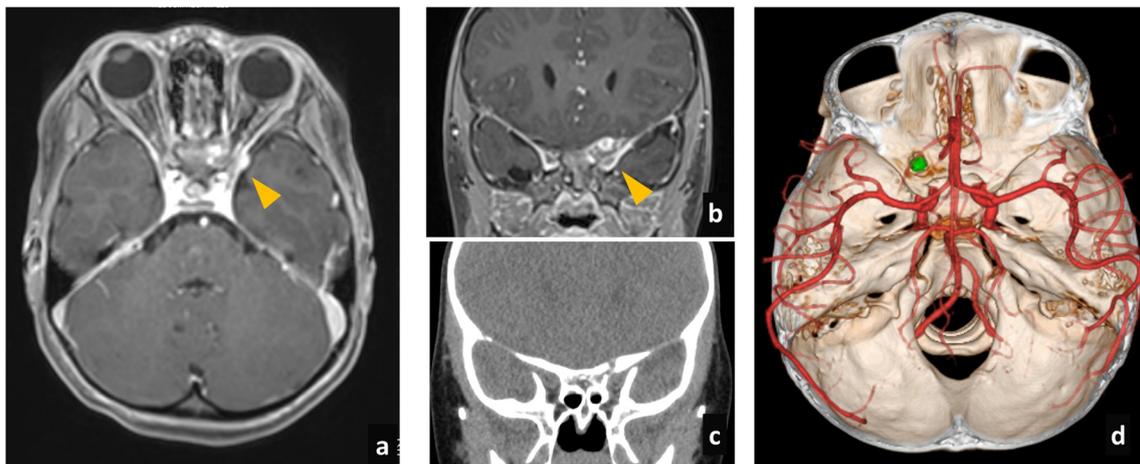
Axial and coronal views show the enhancing lesion at the roof of the left optic canal (arrowhead) (a, b). Local osseous erosion in the left sphenoid bone is revealed on CT (c). 3D reconstruction imaging demonstrating bony erosion and the mass lesion (d)
